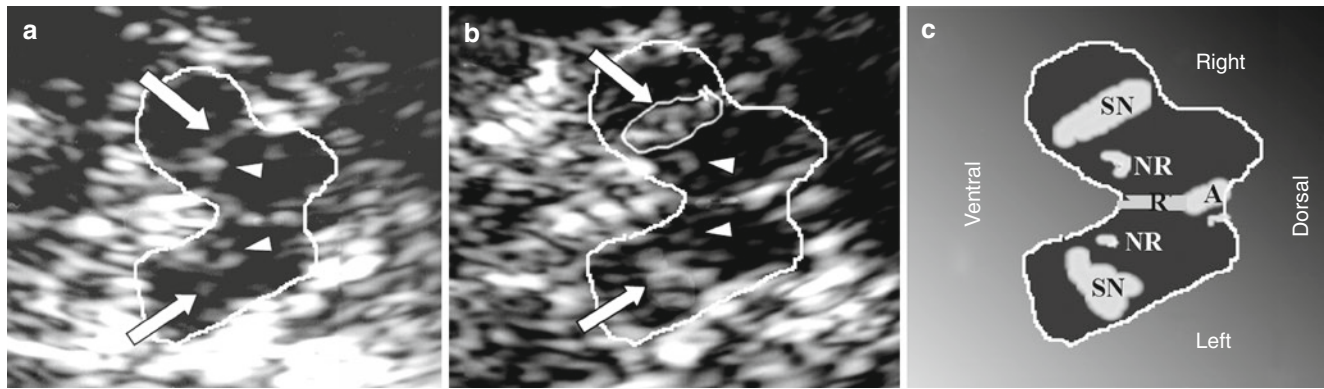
Substantia nigra in axial sonogram of the midbrain. (a) Unremarkable finding: the substantia nigra is viewed as a delicate echogenic band- or patch-shaped structure (arrows). Also readily identifiable is the border echo of the red nucleus bilaterally (arrow heads). (b) Pathologic finding: the substantia nigra is markedly hyperechogenic
